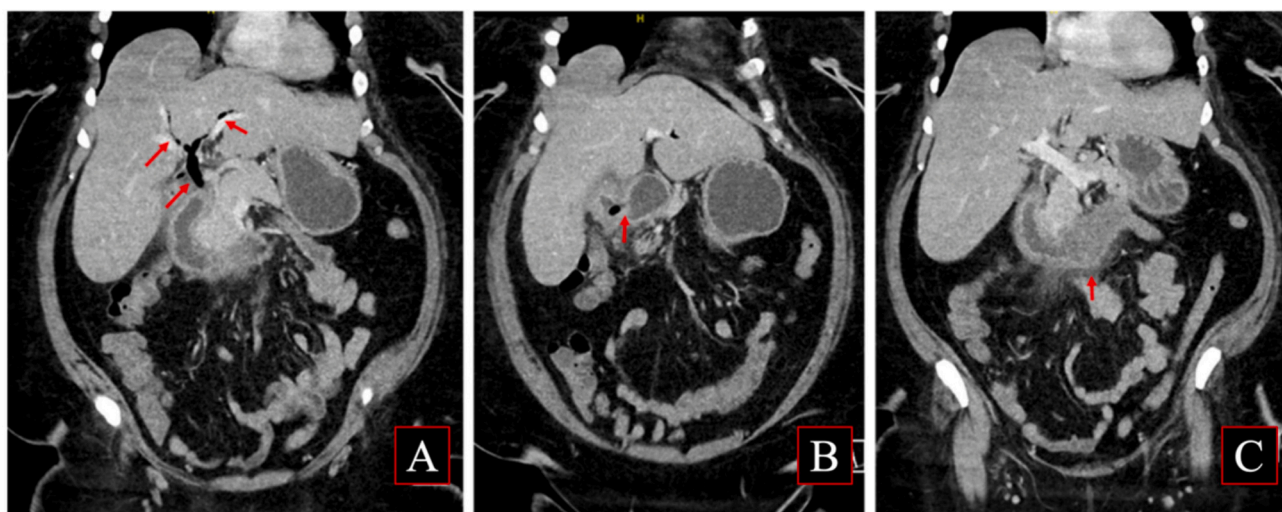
Contrast-Enhanced CT Scan of the Abdomen and Pelvis
